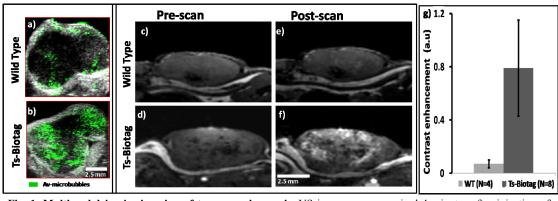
Multimodal *in vivo* imaging of tumor angiogenesis. US images were acquired 4 minutes after injection of Av-Microbubbles in WT (a) and *Ts-Biotag* melanomas (b), using an acquisition sequence for nonlinear detection of microbubbles (green) [5]. MRI images were obtained pre (c,d) and 1h post (e,f) injection of Av-DTPA-Gd, showing contrast enhancement in the *Ts-Biotag* (f), but not in WT tumor (e). Contrast enhancement from MRI images was quantified in both WT and *Ts-Biotag* tumors (g)
